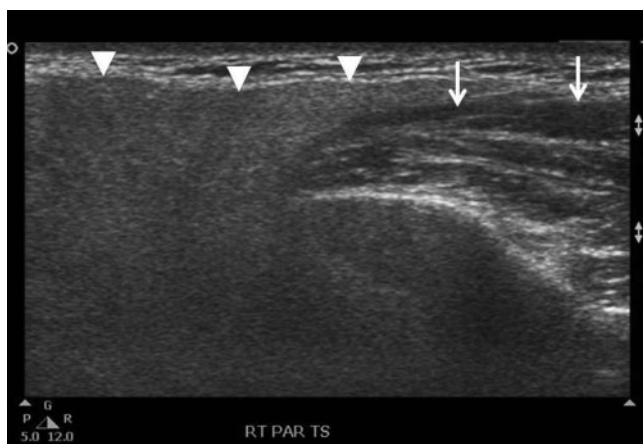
Sonogram shows a transverse scan of a normal parotid gland (arrowheads), which is hyperechoic compared with the adjacent masseter muscle (arrows).
